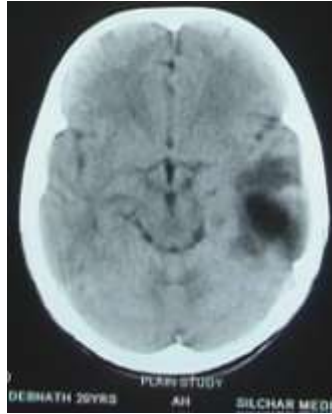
CT brain showing Stage 2 (latent or quiescent) of abscess formation.
